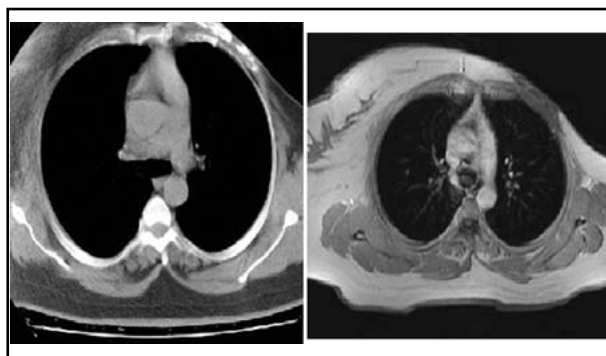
CT and MRI revealed a hyperintense fluid collection in the left breast area with a size of 47x17 mm at the widest area and osteomyelitis in the left anterior 3rd, 4th and 5th rib and fibrous tissue appearance in the skin and subcutaneous tissue was reported in the adjacent area.
